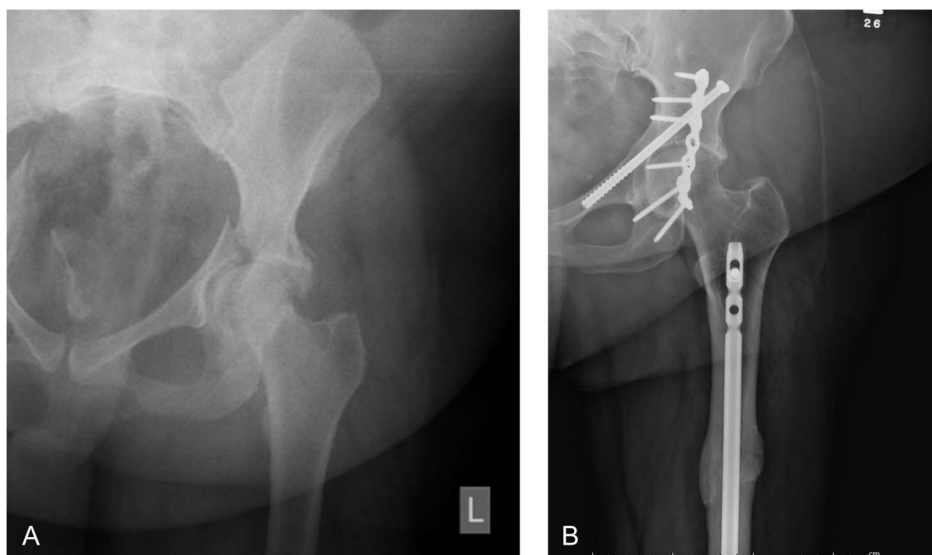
A and B, Plain anteroposterior pelvic radiographs of a patient with an acetabular fracture and associated femoral shaft fracture preoperatively and postoperatively.
